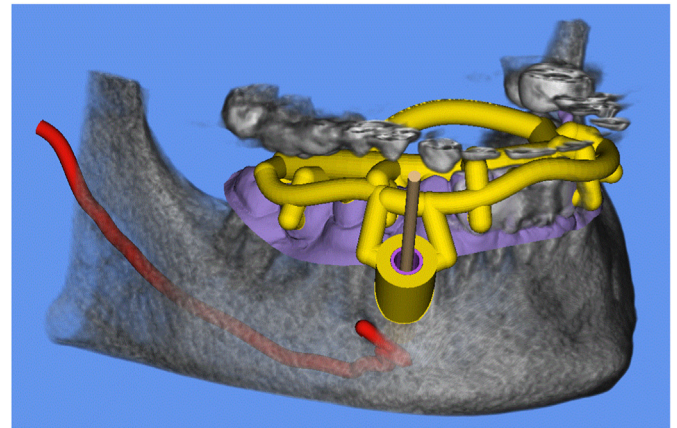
Superimposed and aligned cone beam computed tomography scan (grey), dental scan (purple), and a digitally designed drilling template (yellow) with a guide for the trephine bur (Case 9).
